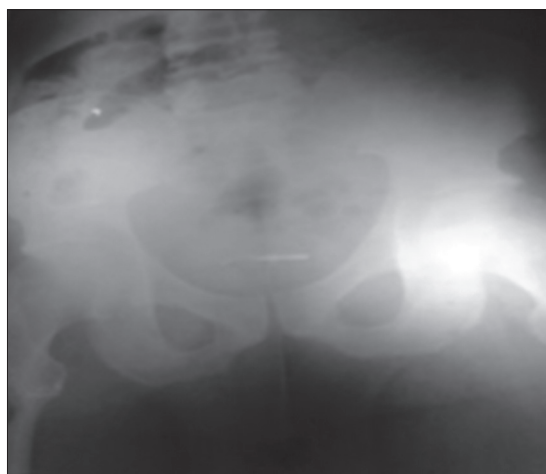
Plain X-ray showing transverse-lying earphone jack in the bladder
